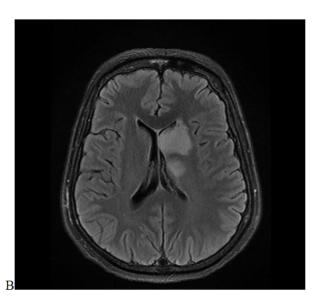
Axial T2 (A) and Axial FLAIR images (B) weighted Brain MRI revealed an acute ischemic stroke in the anterior choroidal artery territory with high-signalintensity lesions involving the posterior limb of the left internal capsule, left basal ganglia, left thalamus
